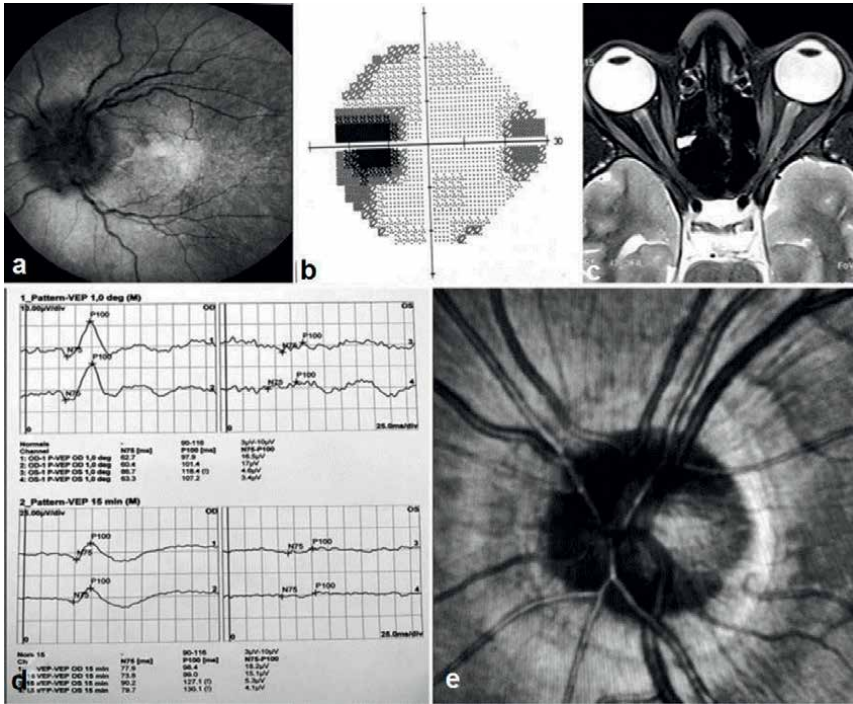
(a) Fundus showing swollen optic disc with blurred margins in LE. (b) AP showing enlarged blind spot. (c) MRI brain and orbit showing enhancement of the left optic nerve. (d) VEP showing flat waves in LE. (e) Fundus picture showing reduced swelling of the disc on follow-up.
